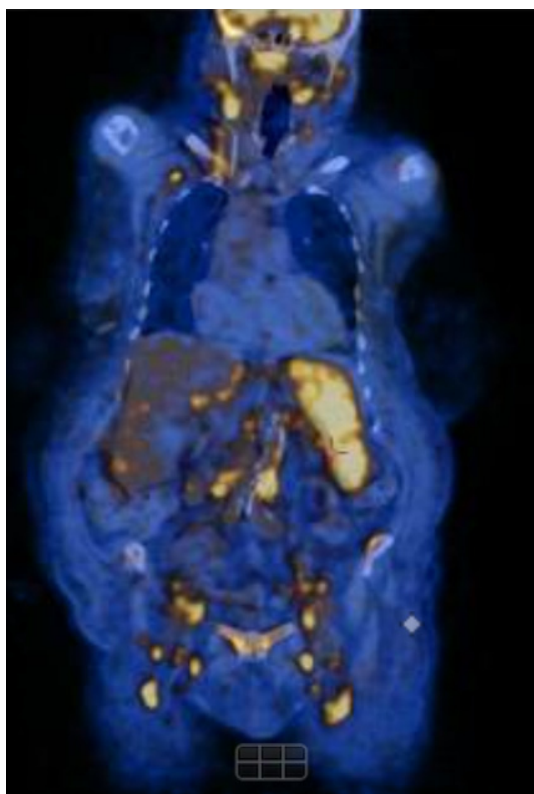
PET-CT showing lymphadenopathy and splenomegaly.
